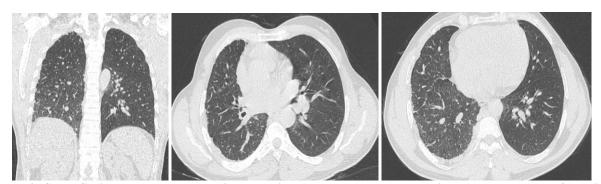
Chest CT in the parenchymal window, axial and coronal planes, showing reduced volume of the right lung with thickening of septal and non-septal lines, associated with perfusion abnormalities
